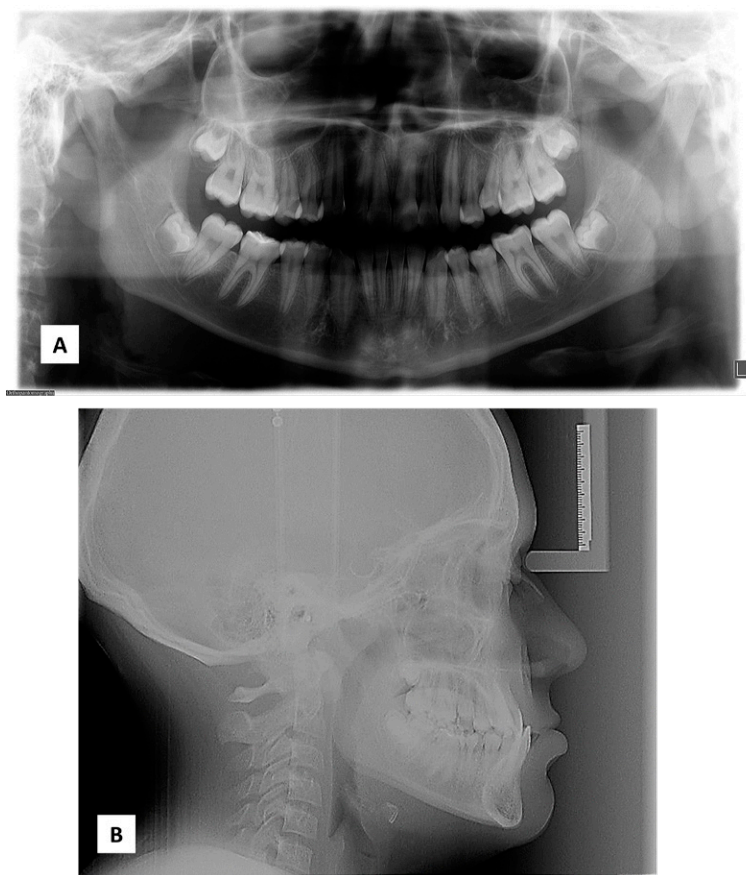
Initial radiographic images. A. Orthopantomography. B. Lateral headfilm.
